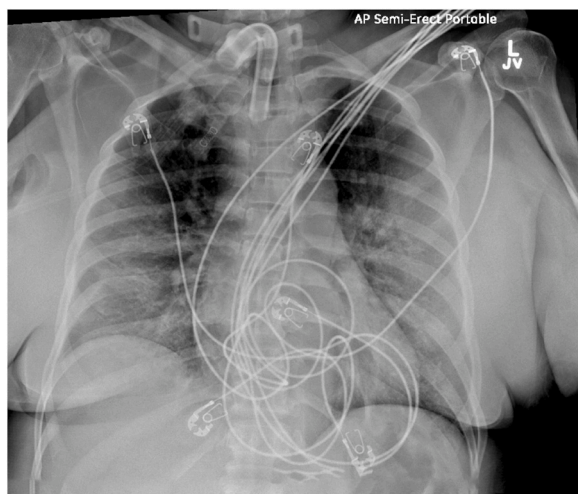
Chest radiograph Day 12: Diffuse bilateral infiltrates.
